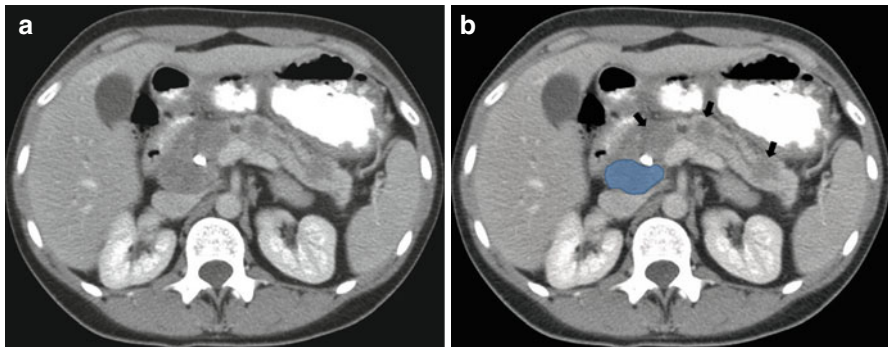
(a, b) Axial CT image in a patient with metastatic sarcoma with multiple metastases to the pancreas (*arrows*) and to the superior pancreaticoduodenal lymph node (*blue*)
